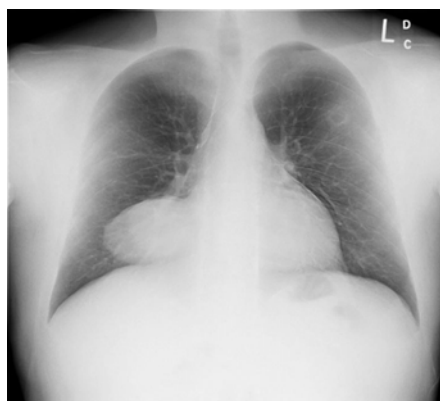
Chest radiograph image showing a mass projected over the right lower chest.
